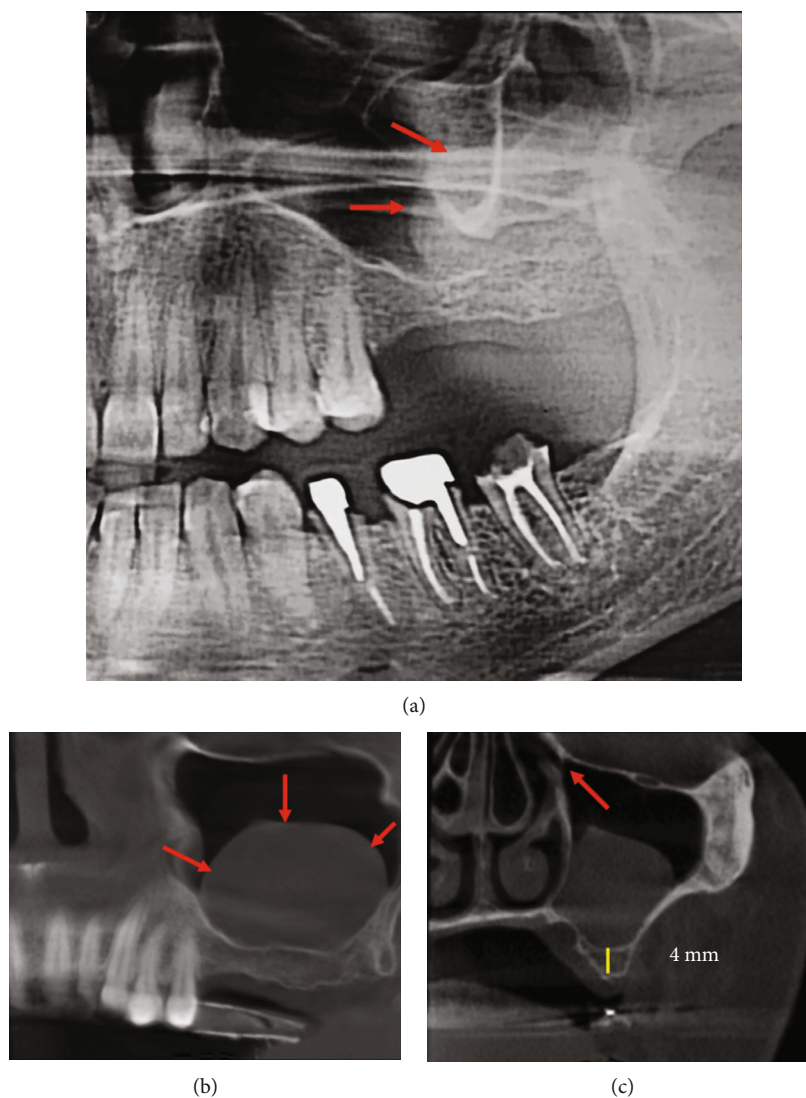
(a) Panoramic radiograph showed a radiopacity in the left maxillary sinus (arrow: border of the cyst). (b) A sagittal cut of the CBCT displayed a round-shaped radiopaque lesion on the left maxillary sinus (arrow: border of the cyst). (c) Axial cut revealed the radiopacity lesion inside the sinus, 4 mm residual bone height, and the ostium remains clear (arrow: ostium).
